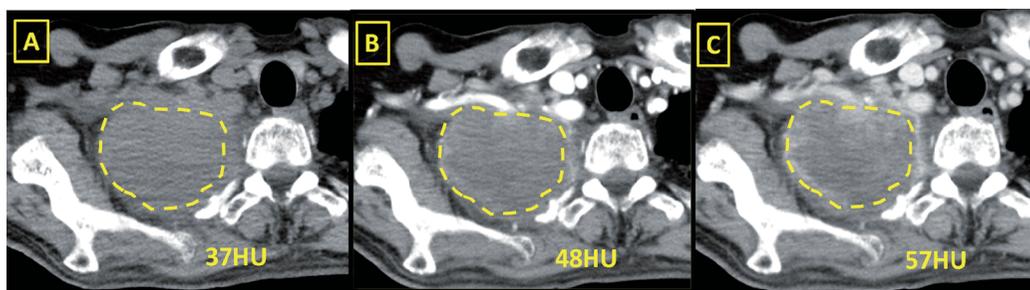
The volume of blood supply to the tumor defined by the CT value (HU; Hounsfield Unit). The maximum dimension of tumor on dynamic CT ([A] non-enhanced, [B] early phase, and [C] delayed phase) were encircled by freehand with the disengagement of bony structures, and the CT values of the encircled area were measured using the syngo Dual Energy Lung Nodules accessory software program (Siemens Healthcare, Forchheim, Germany). The CT value, which was calculated by subtracting the non-enhanced value from the contrast-enhanced value (divided early phase and delayed phase) was considered to represent the blood supply to the tumor. The CT values of the early phase and delayed phase were 11 and 20 HU, respectively.
